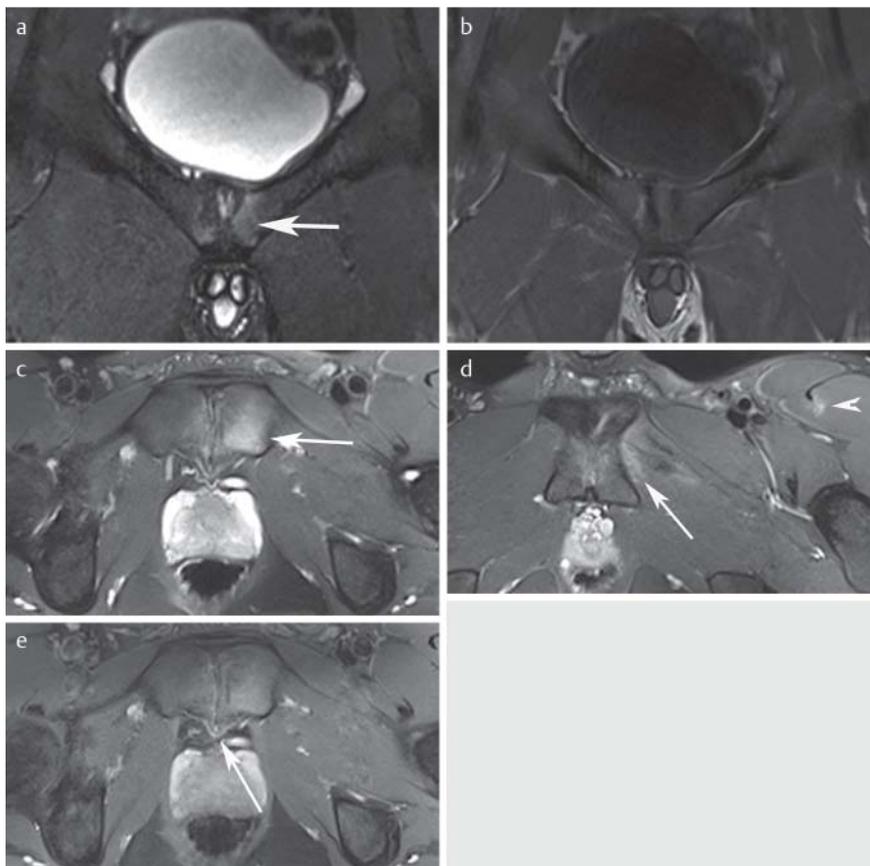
Acute osteitis pubis. 17-year-old youth soccer player with acute osteitis pubis and bilateral subchondral, mainly left-sided parasymphyseal bone marrow edema (arrow), coronal STIR a and coronal T1-weighting b. The maximum or side of the edema frequently correlates to the pain site. c, d Axial, fat-suppressed T2-weighted 3-Tesla MRI of a 20-year-old professional soccer player. Left-side parasymphyseal bone marrow edema (arrow) and edema in the left adductor brevis muscle insertion (arrow), both typical in acute cases. In addition, there is a grade 1 muscle tear according to [19] in the rectus femoris muscle (tip of arrow). A supplementary injection of contrast medium e is necessary only in cases of suspected septic arthritis and provided no additional utility in this case. Further, a posterior herniation of the symphyseal disc (arrow) is present, frequently encountered in competitive athletes, and which can be asymptomatic [6]. It is unclear whether this herniation predisposes to osteitis pubis [2].
